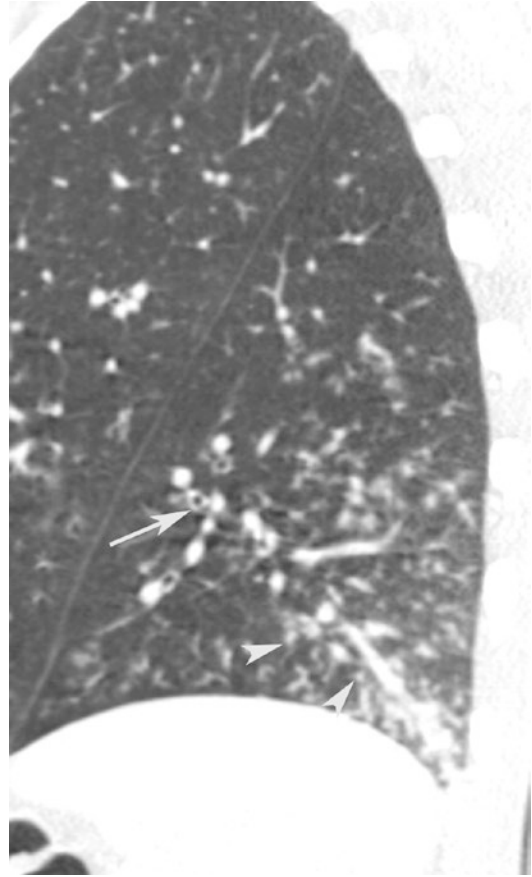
CT sagittal scan shows small nodules (*arrow tips*) associated with thickening of the bronchovascular structures (*arrow*)
